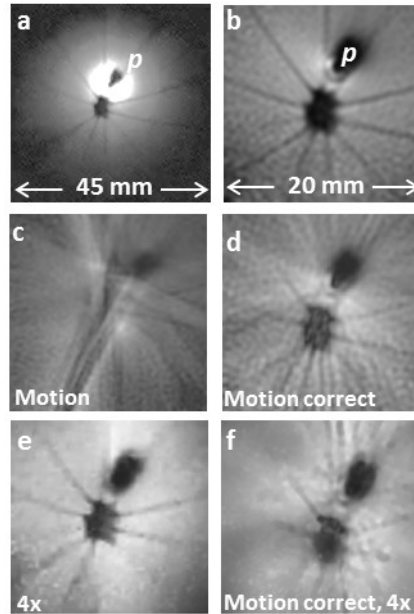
(a) MRI of an orange from internal probe p without the r^{-1} intensity filter and (b) its zoomed version with an r^{-1} intensity filter. (c) MRI of the same orange shaken ± 3 mm showing debilitating motion artifacts. (d) Motion correction substantially restores the image. (e) Fruit morphology revealed in (b) above is retained in a four-fold under-sampled radial CS reconstruction. (f) Four-fold acceleration and motion correction applied to (c) reveals fruit morphology but with some loss of detail in the periphery of the septa.
